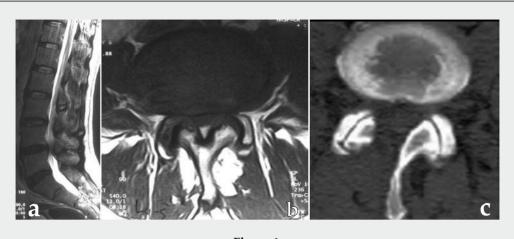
a,b) The preoperative MRI (axial and sagittal images) is seen, c) Postoperative decompression area is seen at postoperative axial CT scan.
